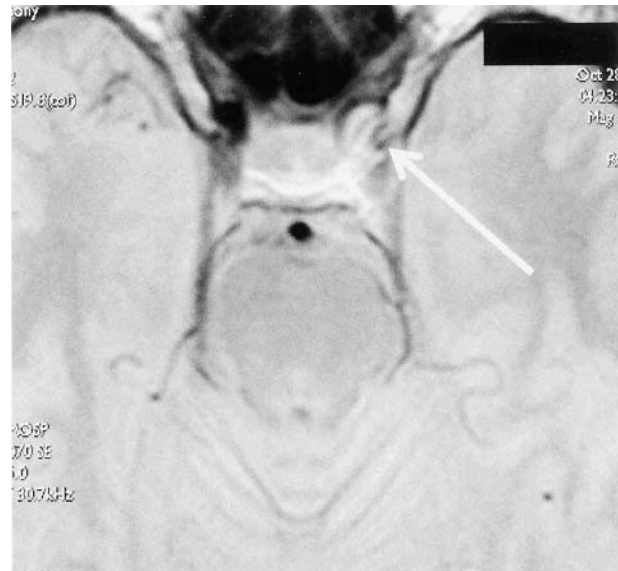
MRI of left internal carotid artery with the site of dissection at the base of skull.
